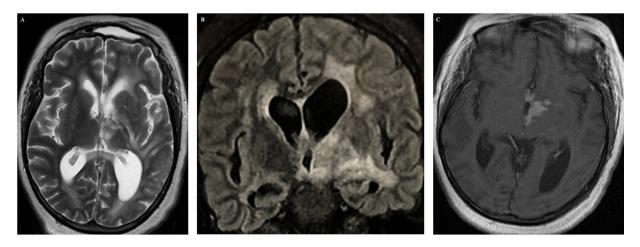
Axial T2 (A), coronal T2-FLAIR (B) and postcontrast T1 (C) sequences show left thalamic lesion extended to the internal capsule, lenticular nucleus, mammillary body and the third ventricle, which is hyperintense on T2 and FLAIR and demonstrate enhancement.
